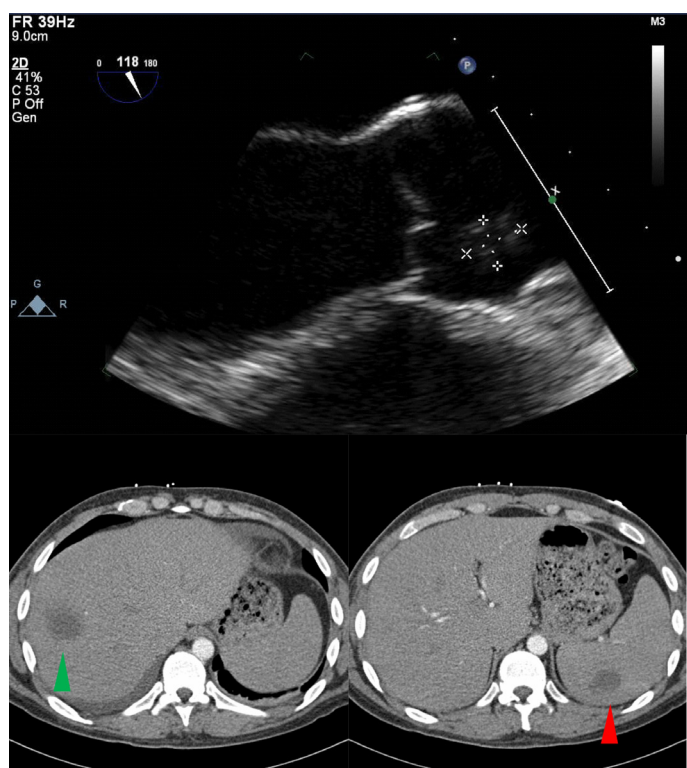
Above transesophageal echocardiogram showing an aortic valve vegetation. Figures 2 and 3 below: computed tomography of the abdomen demonstrating a liver abscess (green arrowhead) and splenic abscess (red arrowhead).
